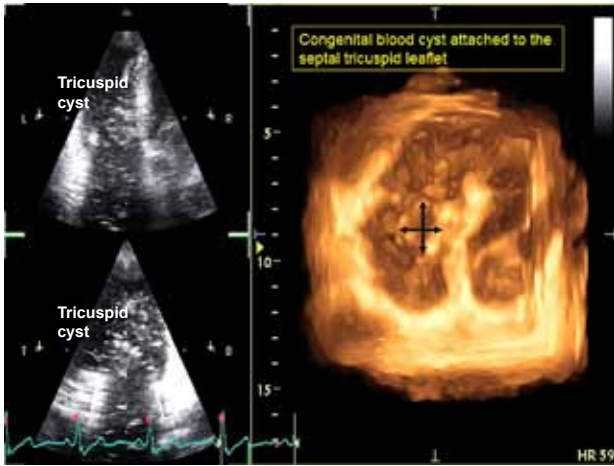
Real-time three-dimensional echocardiography. Reconstruction of the tricuspid valve from the short axis: the cyst is attached to the septal leaflet.
